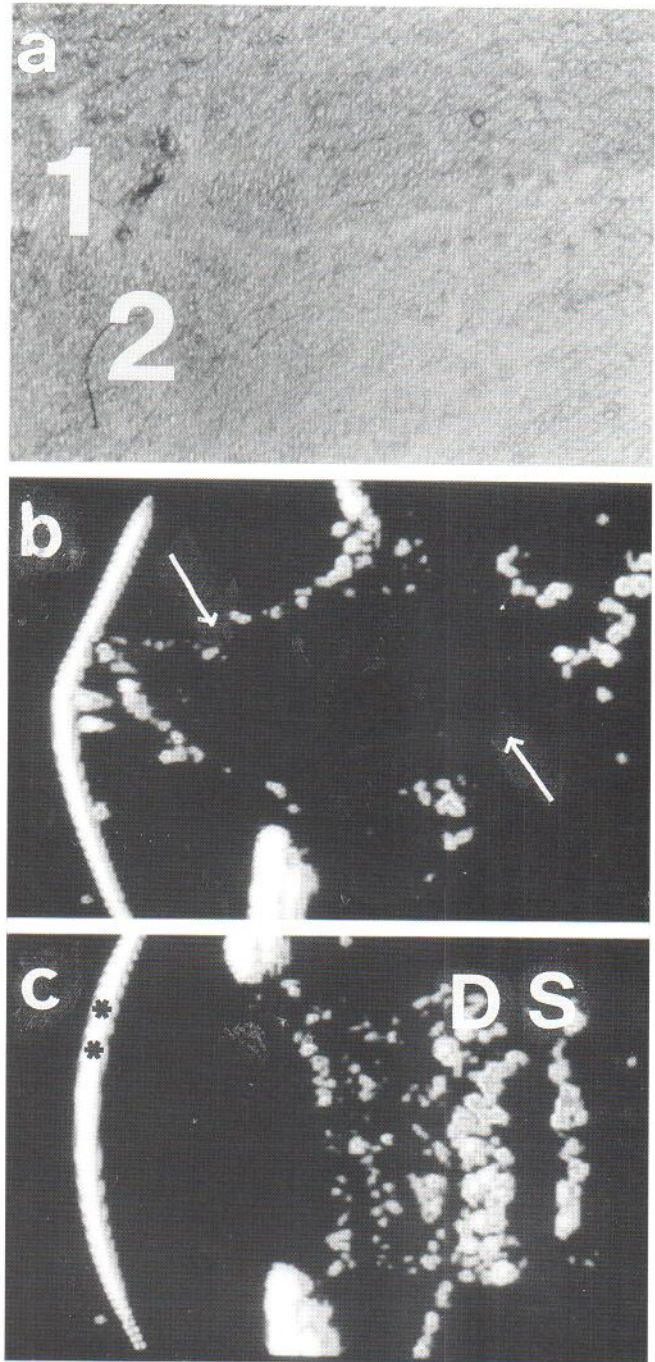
Ultrasound examination of torture-induced scarring. (a) scar on the anterior neck of the torture victim; (b) ultrasound structure of the scar (scanned from place marked 1); (c) the control ultrasound scanning performed in the vicinity of the scar (region 2). D - dermis, S - subcutaneous tissue, arrows - hypoechoogenic scar, \*\* - membrane of the probe.
